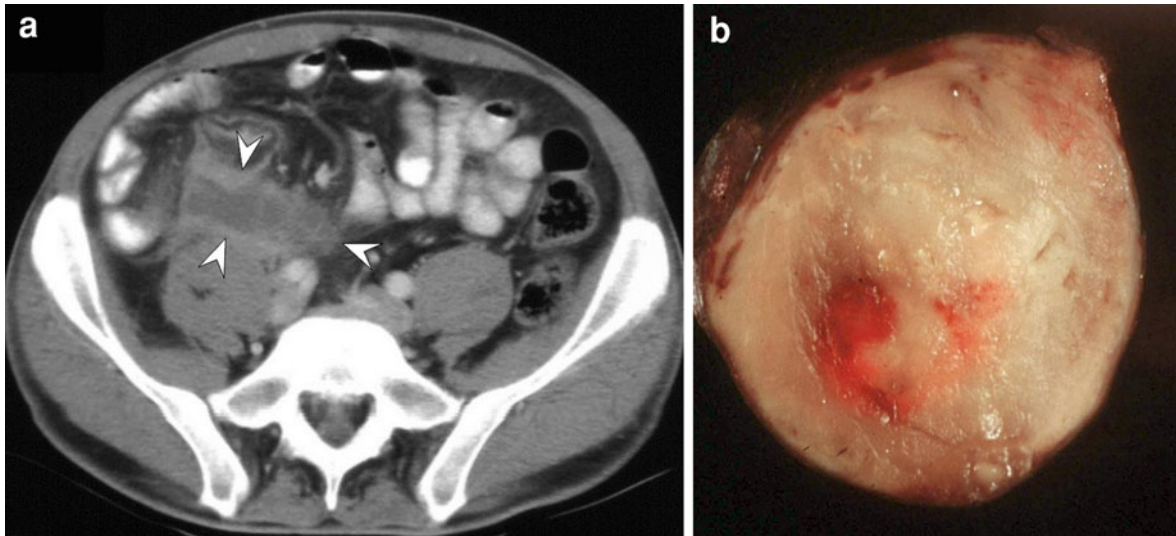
Non-Hodgkin's lymphoma of the appendix presenting with appendicitis. Contrast-enhanced CT image shows a large tubular low-attenuation structure in the right lower quadrant (arrowheads) from circumferential mural lymphomatous
